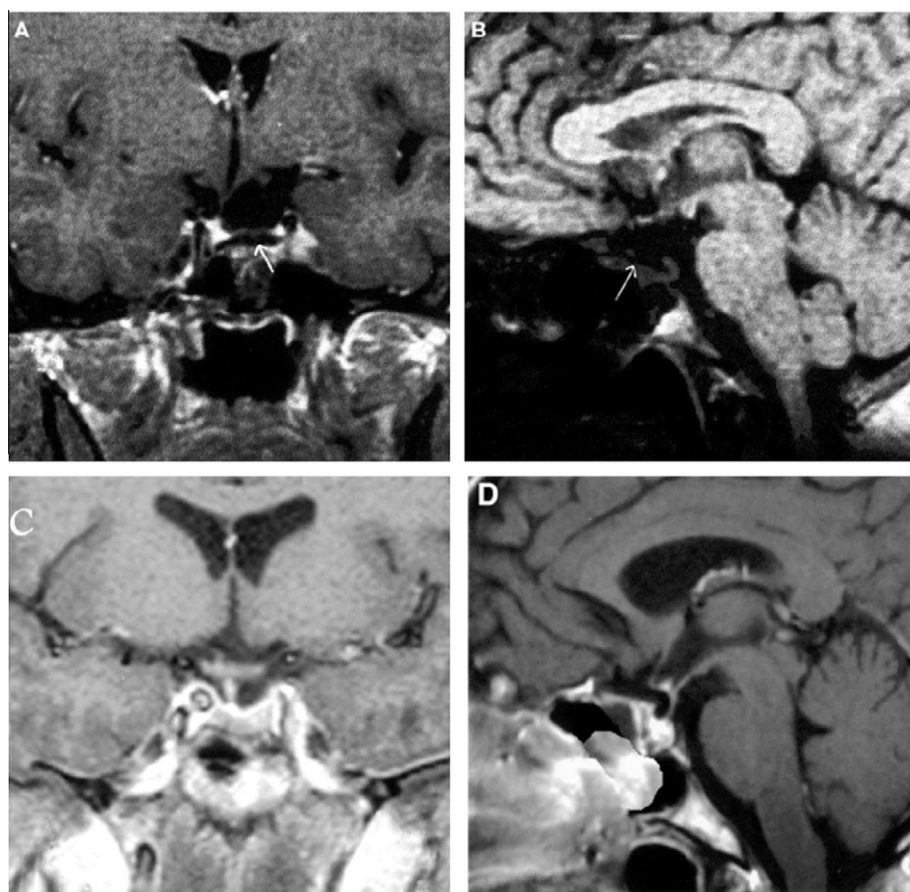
A & B: Preoperative sagittal and coronal T1-weighted MRI in patient with secondary ESS showing downward traction of chiasm, and the stretched pituitary stalk. C & D: Postoperative sagittal and coronal MRI of the same patient 8 months after extradural transsphenoidal packing of the sella with fat showing that the chiasm and pituitary stalk are in normal position.
